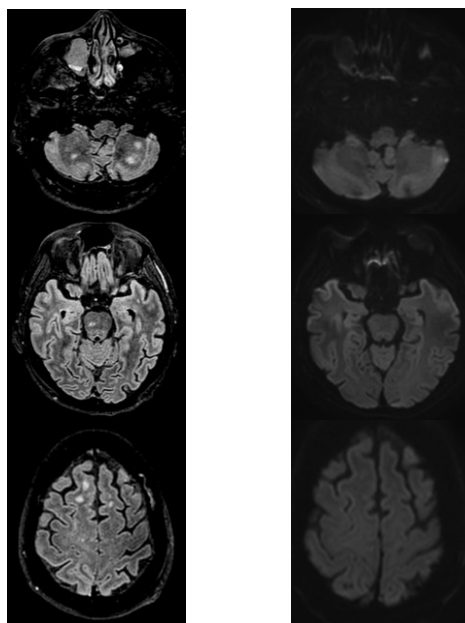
FLAIR VS. DWI sequences. Vasogenic oedema is depicted.
